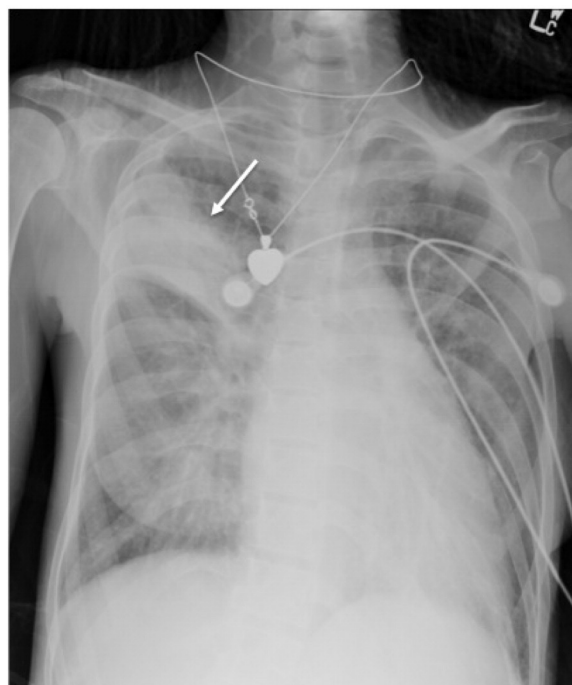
An anteroposterior (AP) view of chest x-ray taken at the time of patient's presentation shows an area of consolidation in the right upper lobe (arrow) as well as diffuse increased interstitial marking and mild cardiomegaly.
